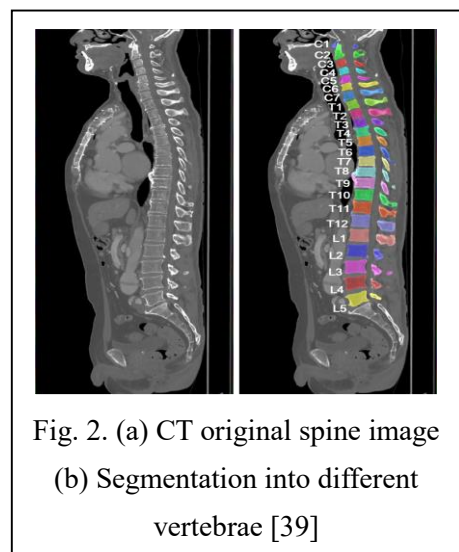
(a) CT original spine image
